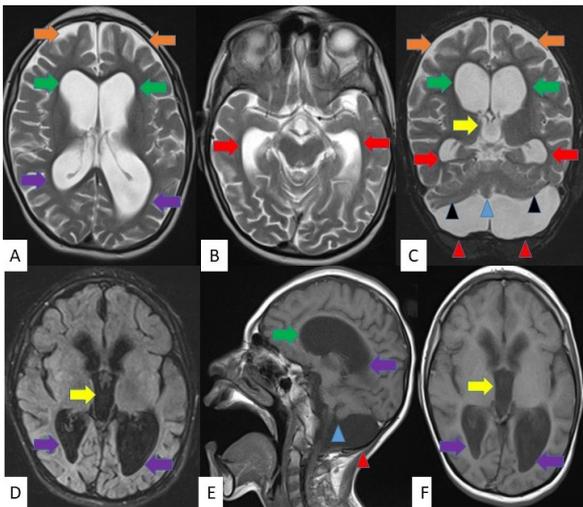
From left to right from top to bottom (A-F); on axial T2-weighted (A-B), coronal fat-suppressed T2-weighted (C), FLAIR (D), sagittal T1-weighted (E) and axial T1-weighted (F) images; In both lateral ventricles, more prominent on the left frontal (green arrows), temporal (red arrows) and occipital horns (secondary to atrophy of white matter especially at this level) (purple arrows), in the 3rd ventricle (yellow arrow), extraaxial CSF distance (to be less) (orange arrows) marked dilatation is observed. There is also cystic dilatation of the 4th ventricle towards the posterior fossa (red arrowheads), and hypoplasia of the cerebellar vermis (blue arrowhead) and cerebellar atrophy (black arrowheads) (Dandy-Walker variant). There is also cerebral atrophy inconsistent with the patient's age.
